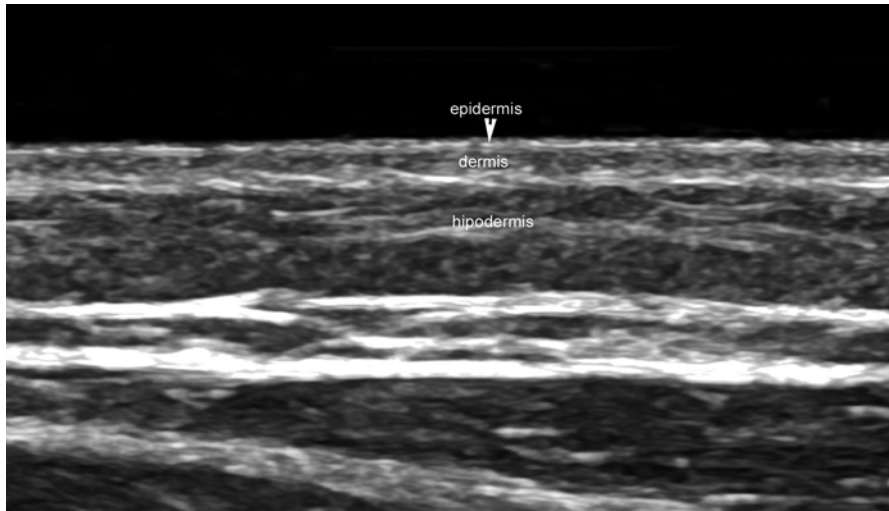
Normal sonographic anatomy of the skin
